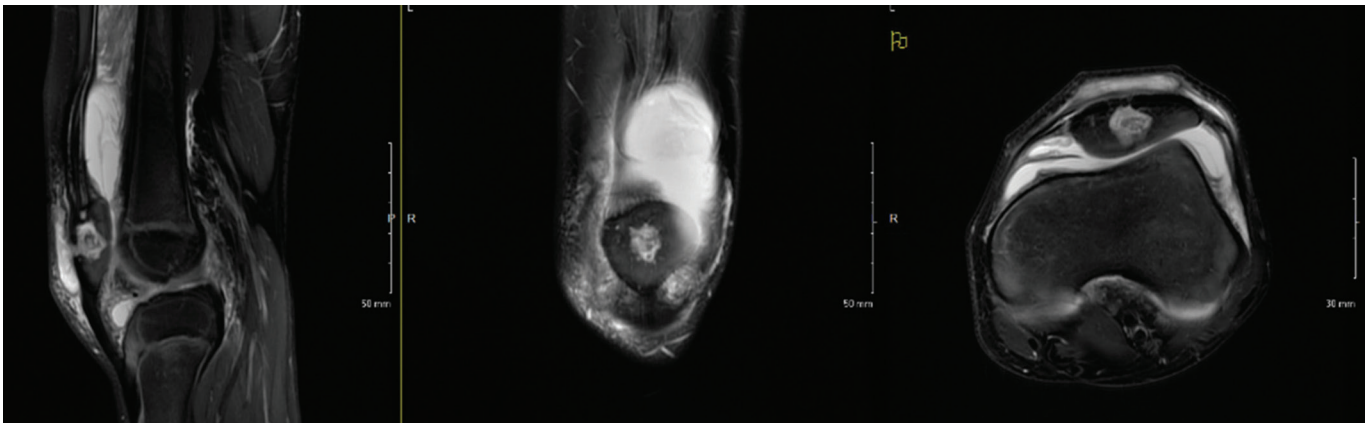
Left knee sagittal, coronal, and axial MRI showing an enhancing lesion in the anterior patella eroding through the anterior cortex of the patella into the prepatellar bursa with knee effusion and thickening and enhancement of the synovium.
